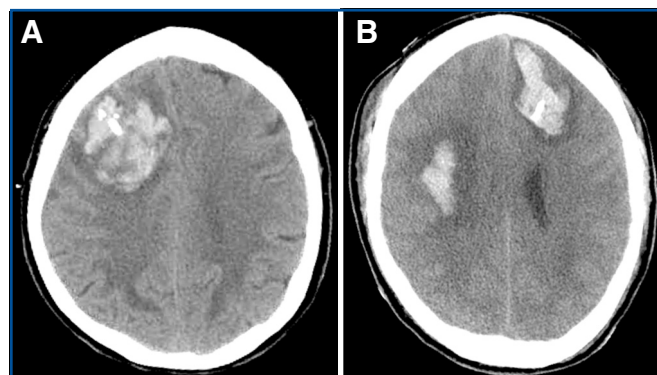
Computed tomographic (CT) scans showing 66-year-old woman (A) and a 54-year-old man (B) with track hemorrhages from external ventricular drain (EVD) catheters managed nonsurgically.
